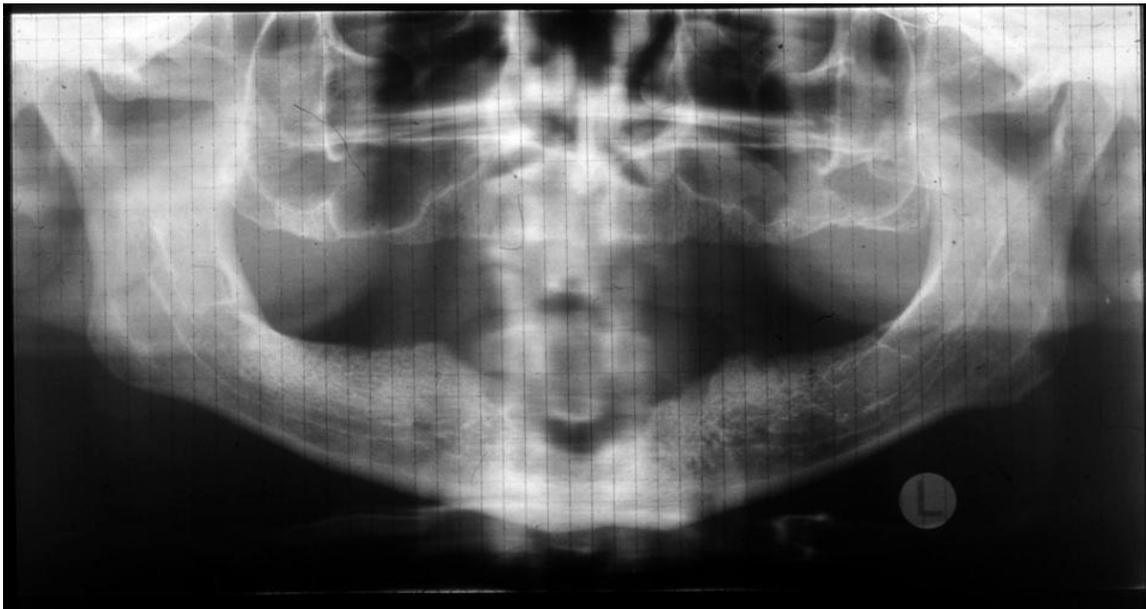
Orthopantomogram on the '5 millimeter grid'
